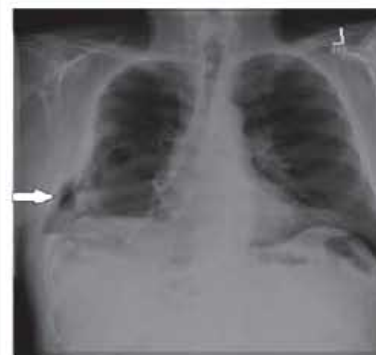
Chest X-ray study showing lucency along the right lateral chest wall
